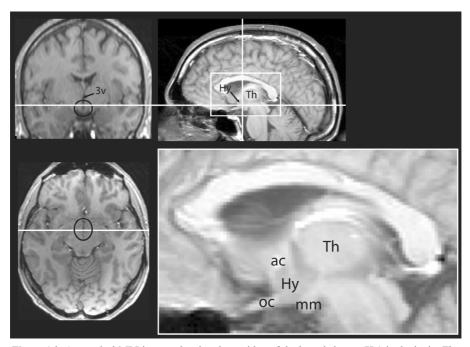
Anatomical MRI-images showing the position of the hypothalamus (Hy) in the brain. The area in the white rectangle is shown enlarged in the lower right corner. The white lines indicate the position of the axial (lower left) and coronal (top left) sections. The black ellipses indicate the approximate position of the hypothalamus. Top left: the hypothalamus lies around the floor of the third ventricle (3v). Lower right: The position of the hypothalamus in the midsagittal plane is given by some anatomical landmarks: it is below the thalamus (Th) and cornered by the anterior commissure (ac), optic chiasm (oc) and mamillary body (mm).
